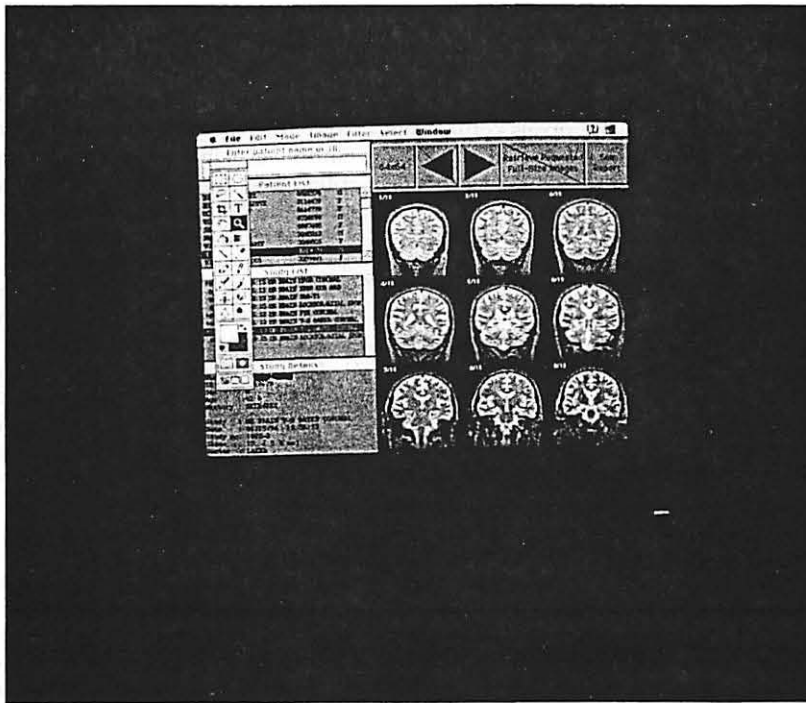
A Macintosh-based editorial and research workstation showing an MR imaging study.
